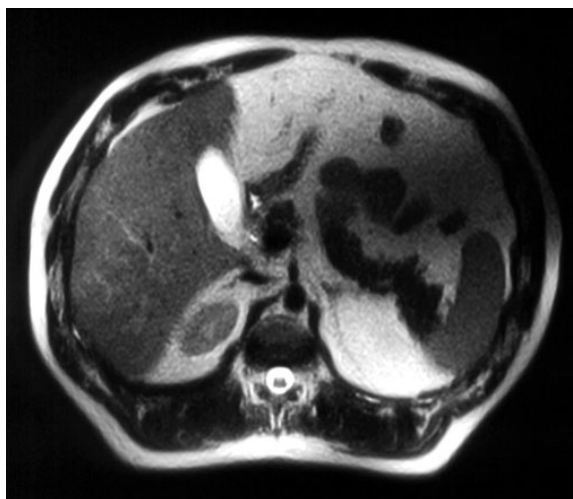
Fatty liver in MR examination. Hiperintense liver parenchyma in T2-weighted axial image.
